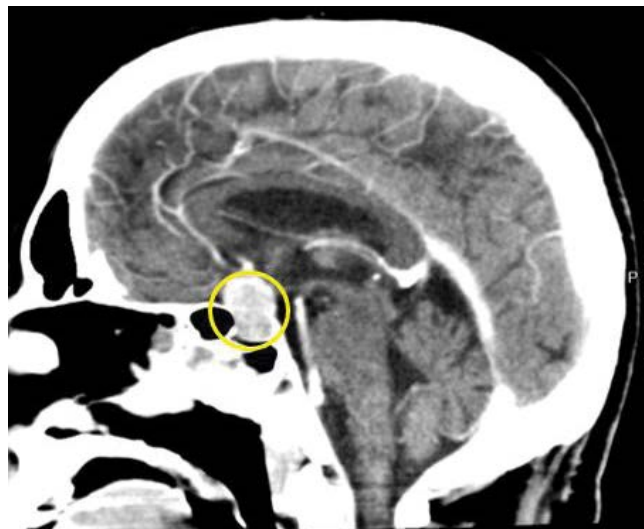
CT Head with contrast: yellow circle depicts a sellar/suprasellar enhancing mass measuring 1.6X1.4X1.9cm consistent with pituitary macroadenoma versus anterior communicating artery aneurysm.
